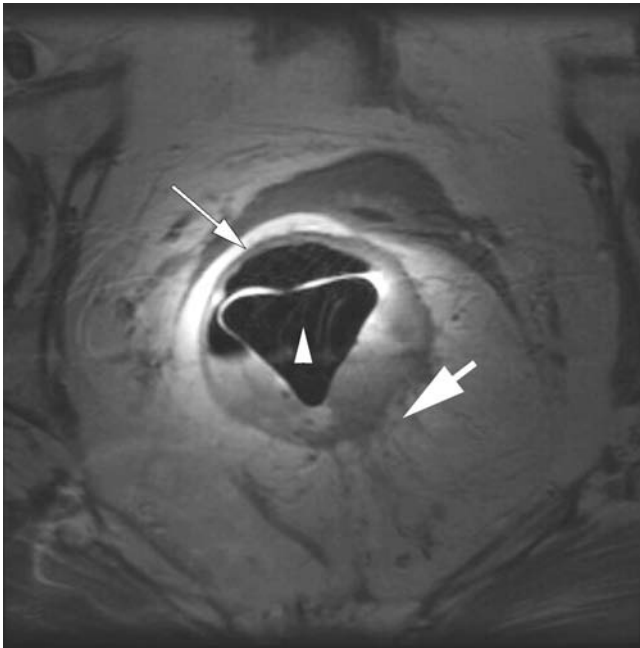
Endorectal MRI of a T₃ lesion. *Arrowhead* indicates the site of the endorectal coil. *Large arrow* demonstrates finger-like projections of carcinoma invading into the mesorectal fat. *Small arrow* points to the anterior rectal wall. (Used with permission from Koensraad J. Mortele, MD, Beth Israel Deaconess Medical Center, Boston, MA.)
